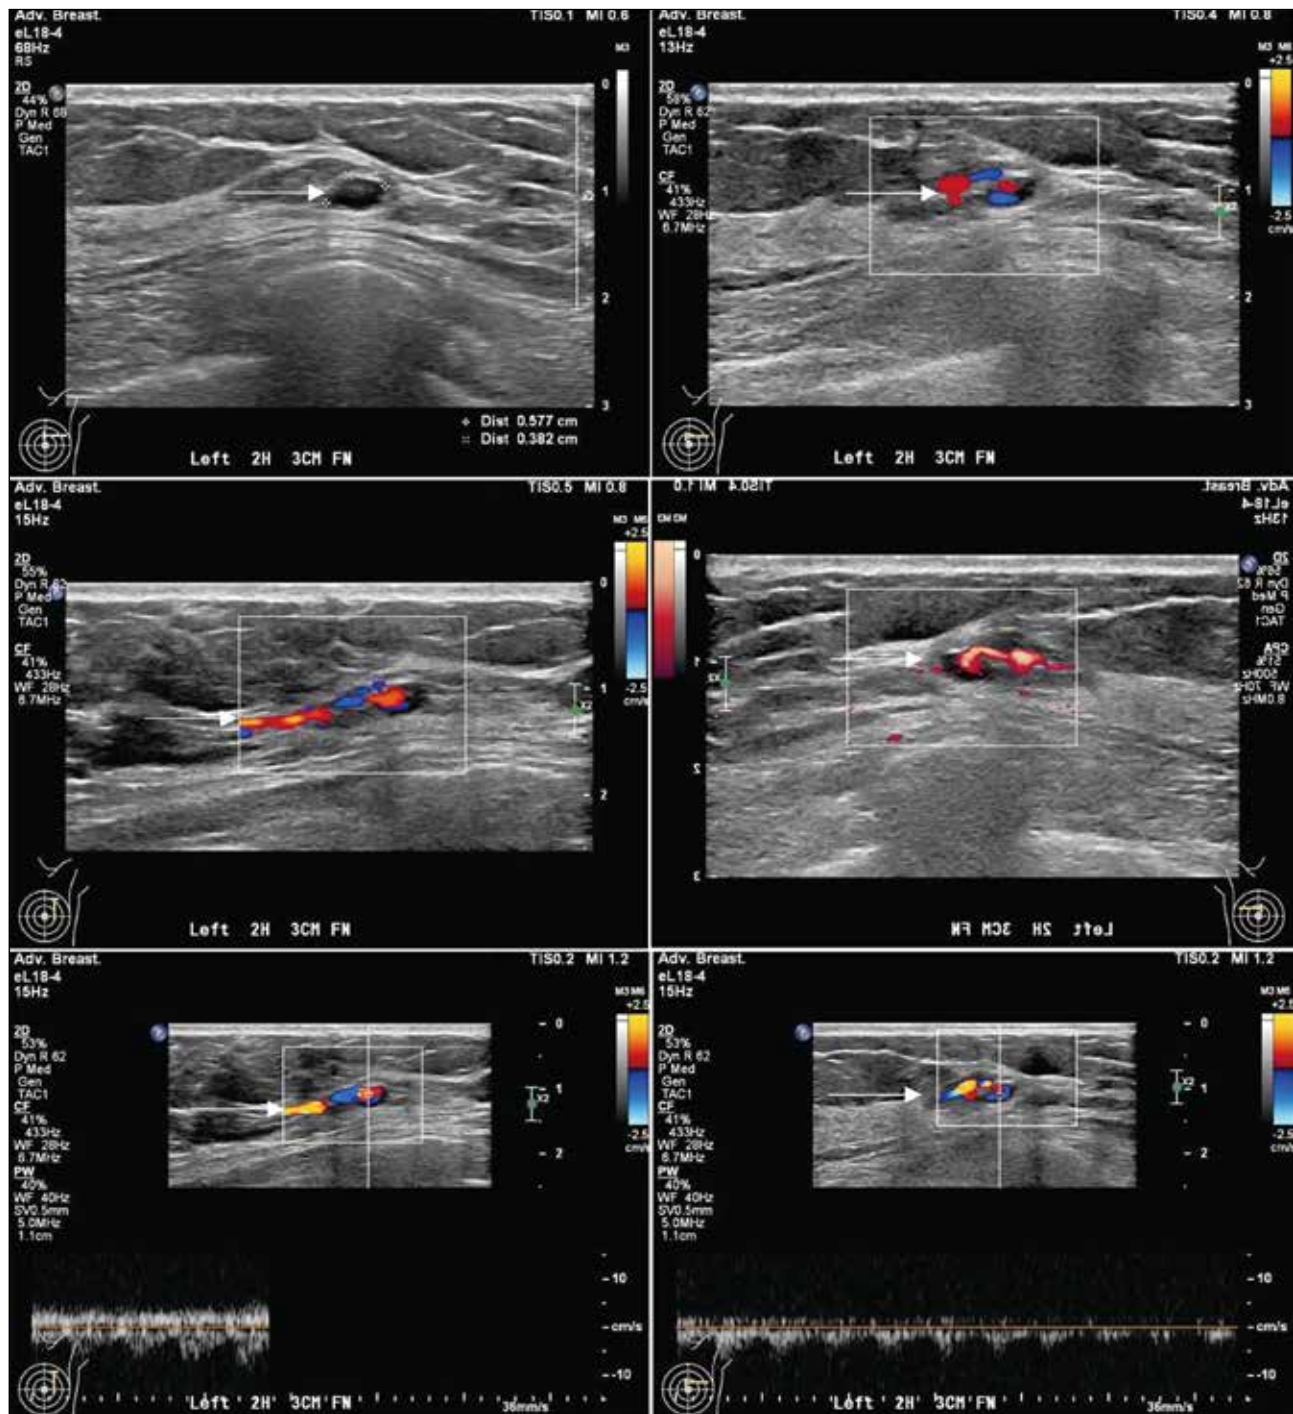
Arteriovenous malformation. Ultrasound of the left breast. At the 2 o'clock position, 3 cm from the nipple, a $0.6 \times 0.4 \times 0.5 \text{ cm}^3$ oval, heterogeneous, hypoechoic mass is visualised with parallel orientation and no posterior acoustic shadowing. It demonstrates internal arterial and venous flow, with communication to adjacent breast parenchymal vasculature (arrows).
